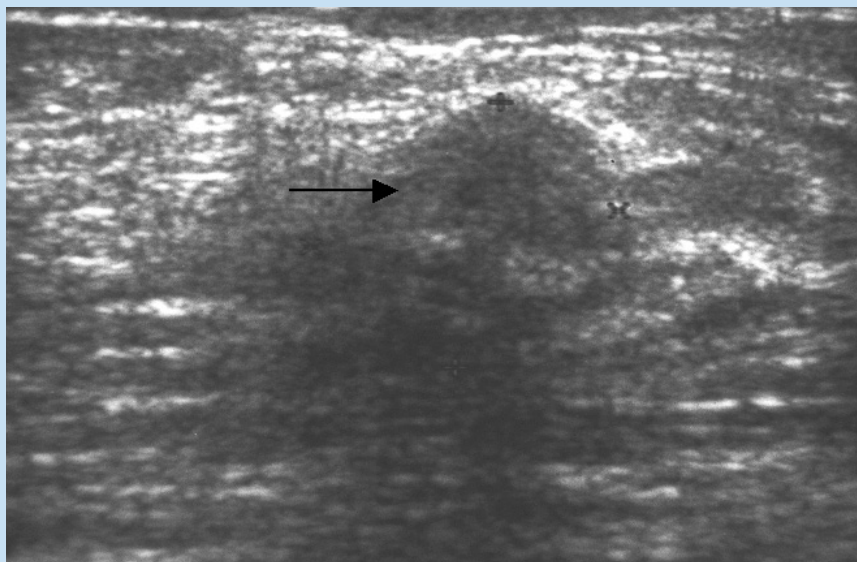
Ultrasound of the left breast demonstrates a 3 cm diameter hyperechoic mass (arrow) that was confirmed to be fibrous mastopathy on biopsy.
